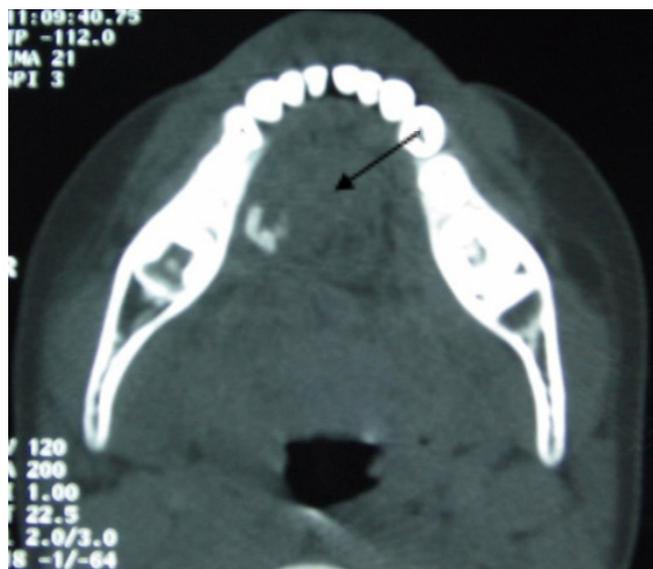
Computed tomography scan: Tumor with soft tissue density associated to a lateral calcification
